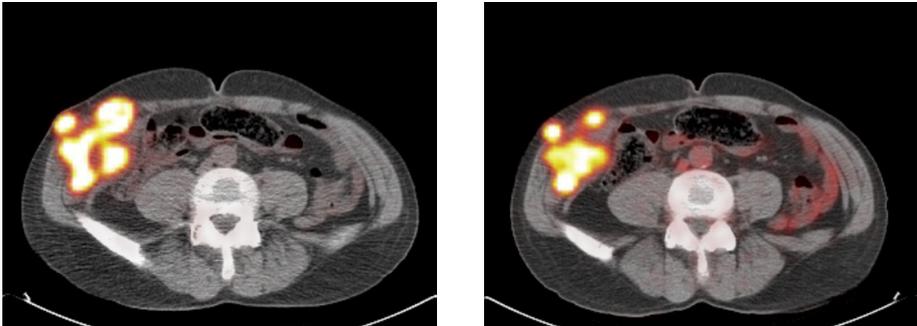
PET-CT fusion images of a 59 year old man with GIST recurrence in the right abdominal wall. The images show significant residual FDG tumor uptake after 2 months therapy with sunitinib. However, the SUV decreased from 13.5 (left image) to 6.4 (right image). Abbreviations: PET-CT, positron emission tomography-computed tomography; GIST, gastrointestinal stromal tumor; FDG, fluorodeoxyglucose; SUV, standardized uptake value.
